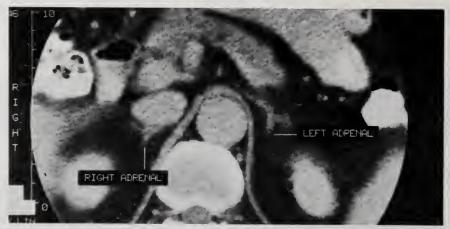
Cephalad section through adrenals. Normal appearing adrenal glands. Higher CT adrenal sections (Fig. 3) showed normal adrenal glands. This emphasizes the importance of narrow collimation and small increments when searching for adrenal tumors. Surgery confirmed a cortical cell adenoma.
